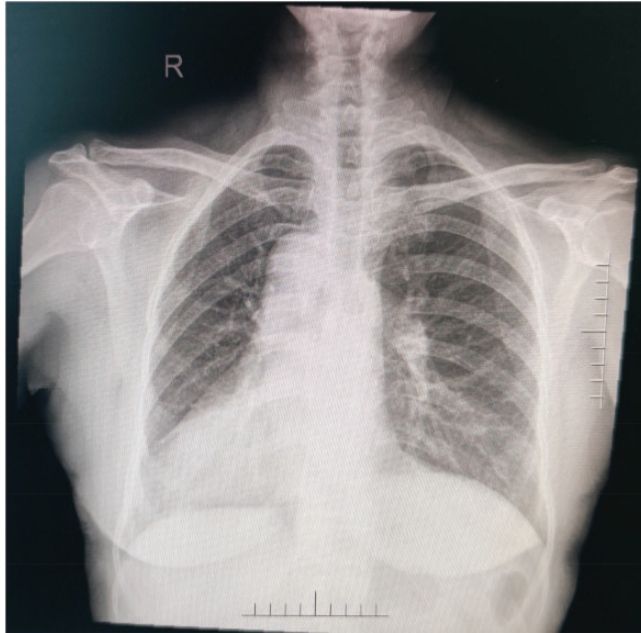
X-ray showing a heart shadow on the right.
